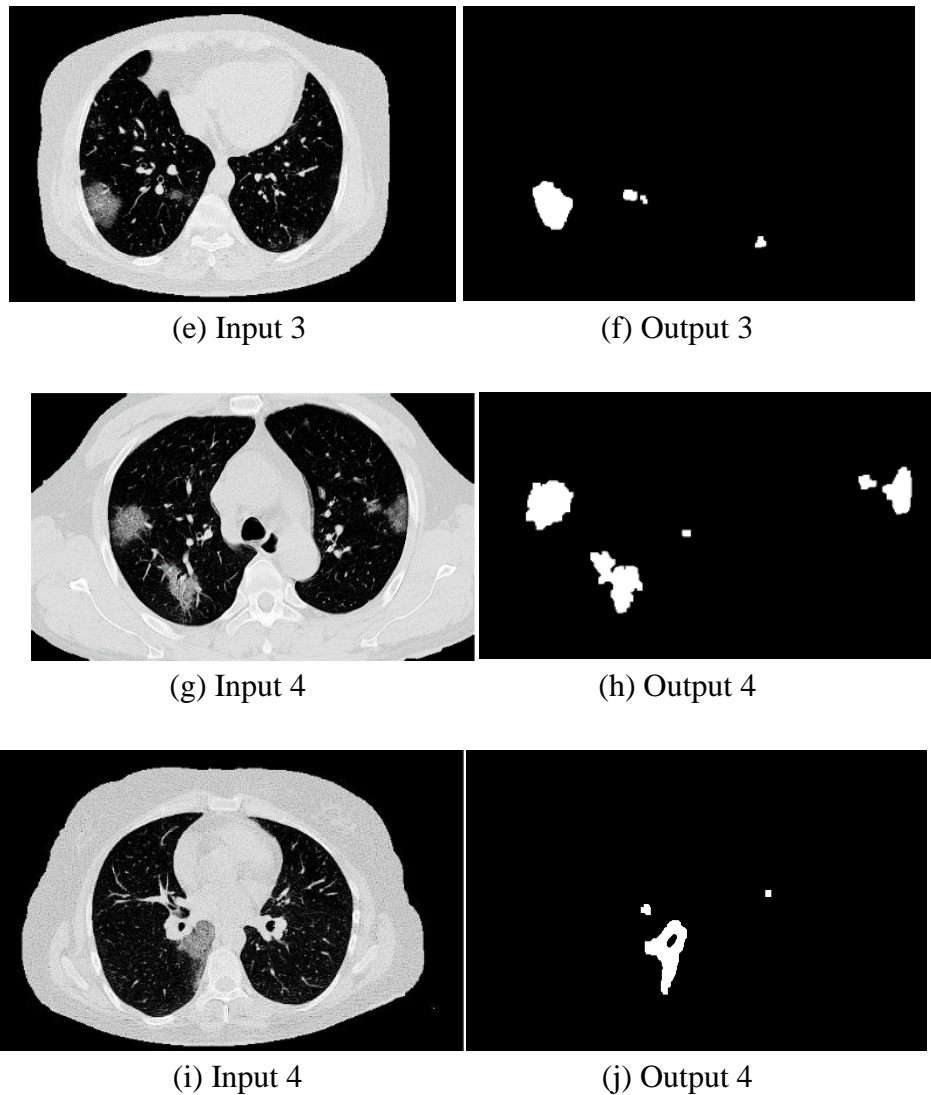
Final inputs and outputs of 4 CT slices of a 51-year-old Covid positive patient
